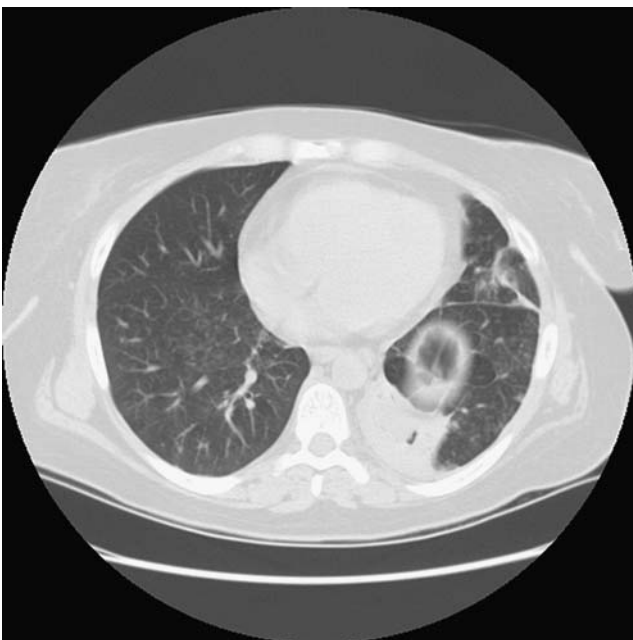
CT scan of chest demonstrating bronchiectatic changes
